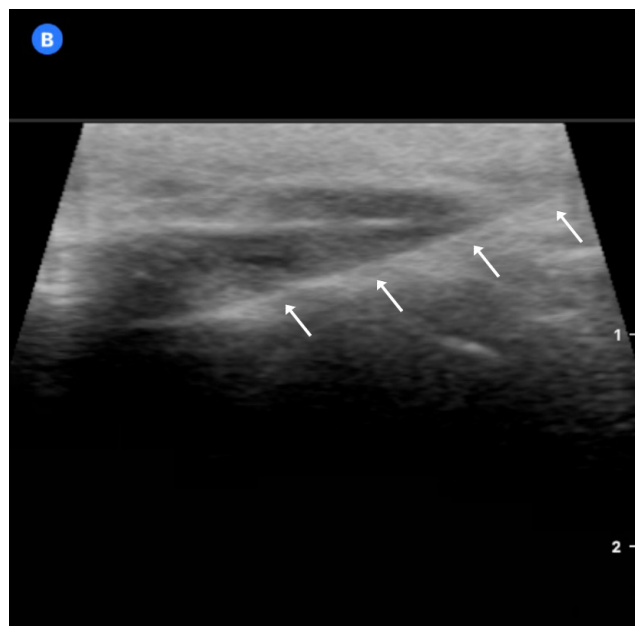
In-plane needle insertion for upper joint space injection under ultrasound (US) guidance (the needle is marked with white arrows for academic reasons)
